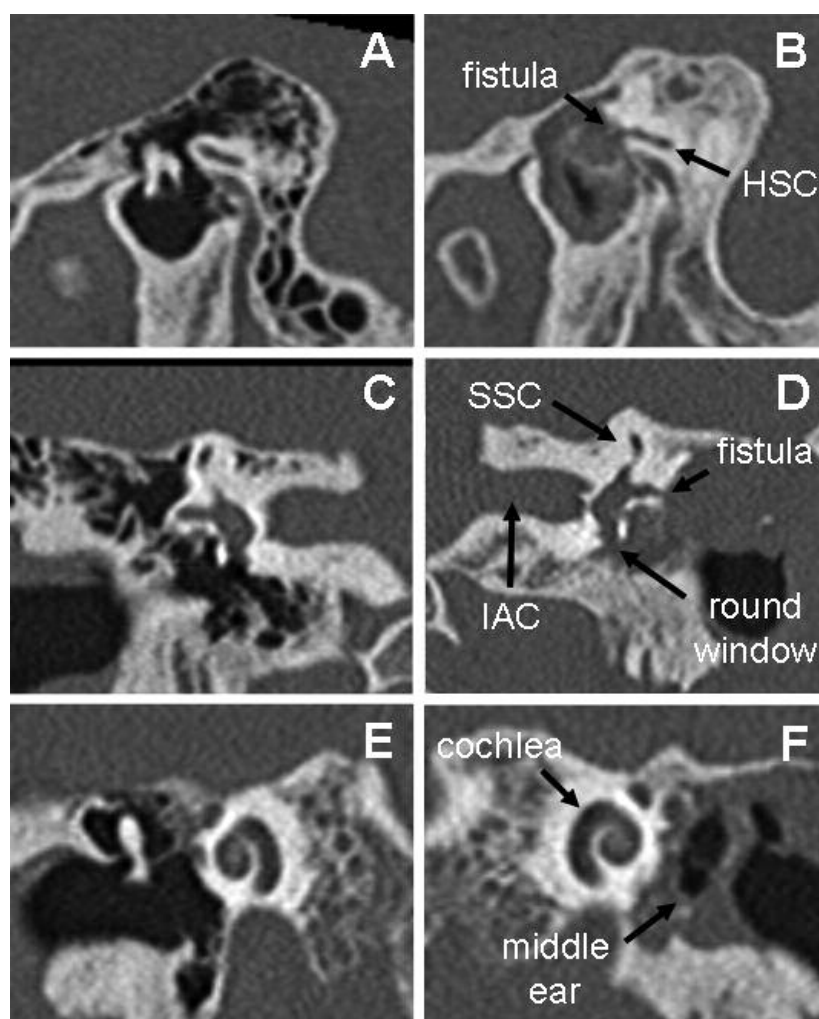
Computed tomography (CT) images of the right (A, C and E) and of the left ear (B, D and F). Oblique sagittal images (A and B) show soft inflammatory tissue in the left middle ear and loss of integrity of the HSC wall in B. Compare panel B vs. panel A. Coronal images (C-F) confirm the fistula of the HSC (D). Compare panel D vs. panel C. No differences between right and left side are seen at the level of the cochlea. Note erosions of the ossicular chain on the left side. HSC = horizontal semicircular canal; IAC = internal auditory canal.
